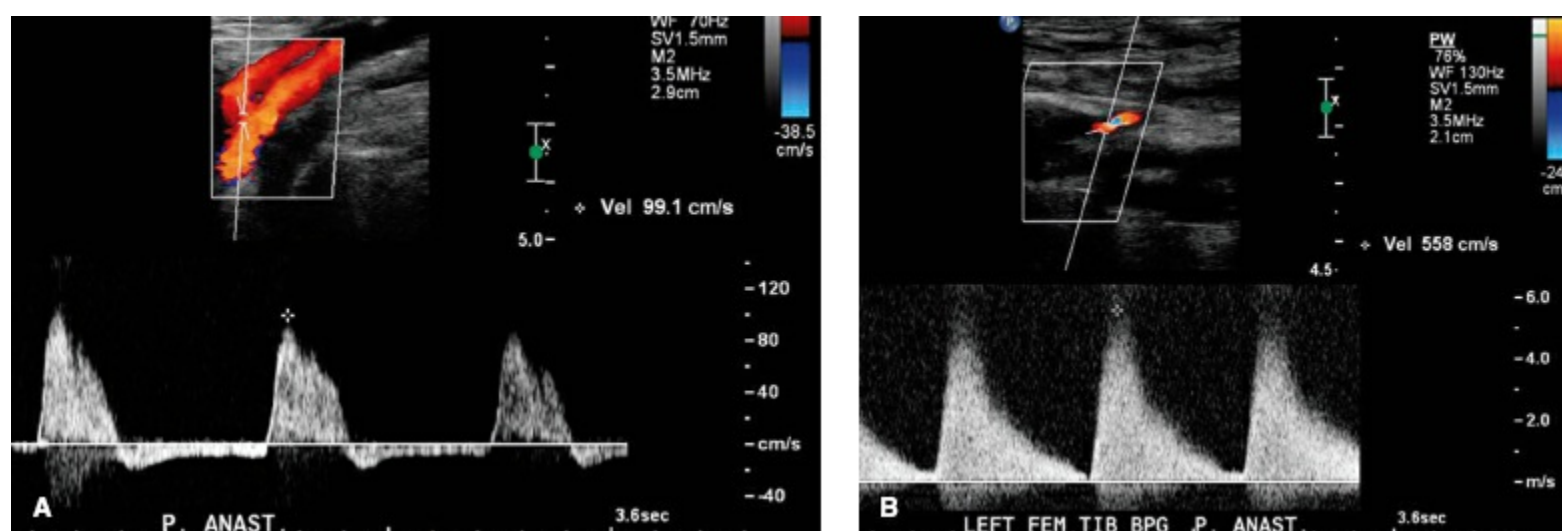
A and B: Duplex ultrasound images and velocity waveforms of normal (A) and stenotic (B) proximal anastomoses of femoral tibial bypass grafts. The abnormal study has a severe elevation in flow velocity of 558 cm/s indicating a high-grade stenosis.
